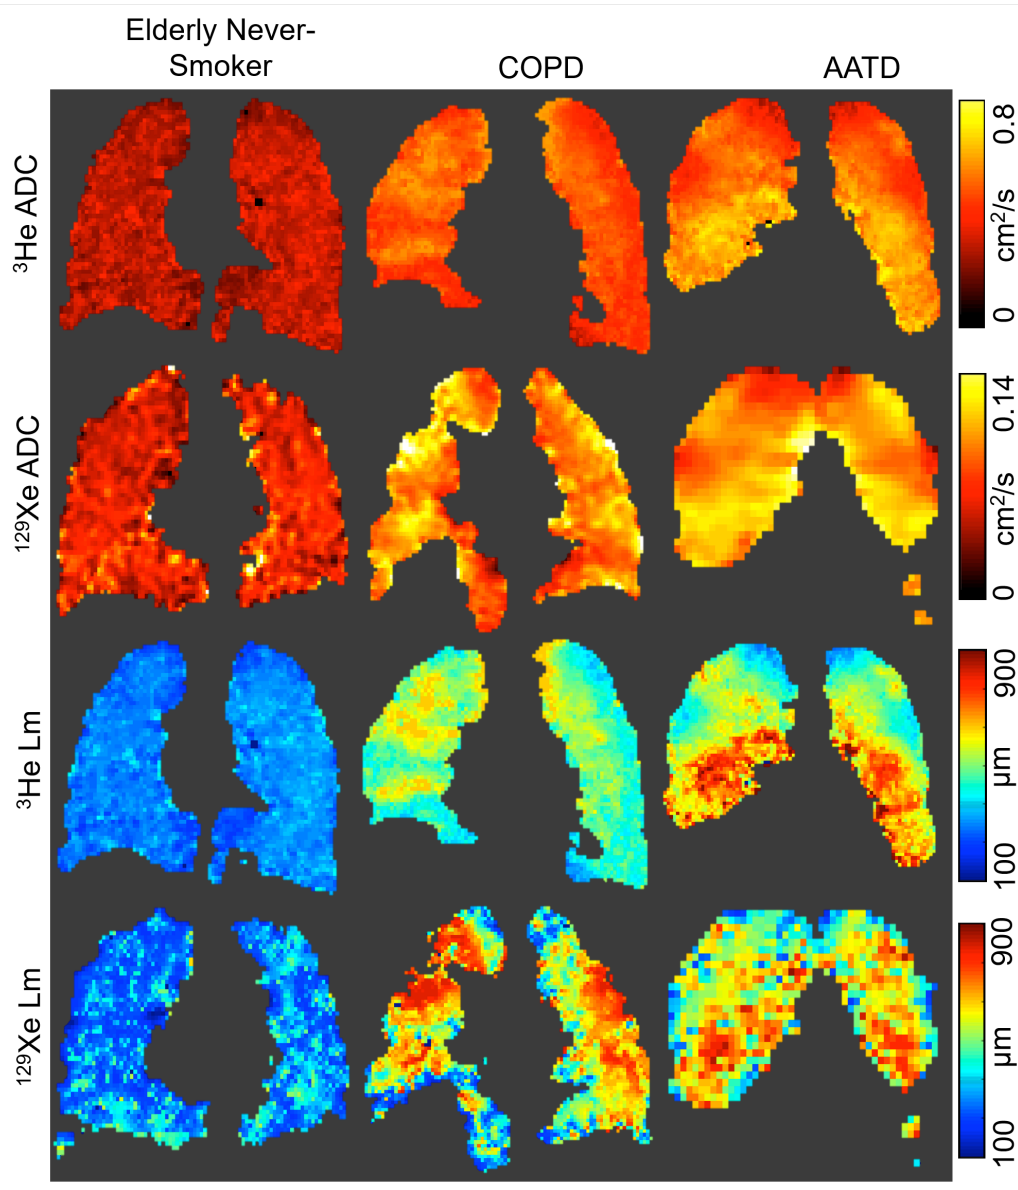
Diffusion-Weighted ^3He and ^{129}Xe MRI Mean Linear Intercept and ADC Maps
